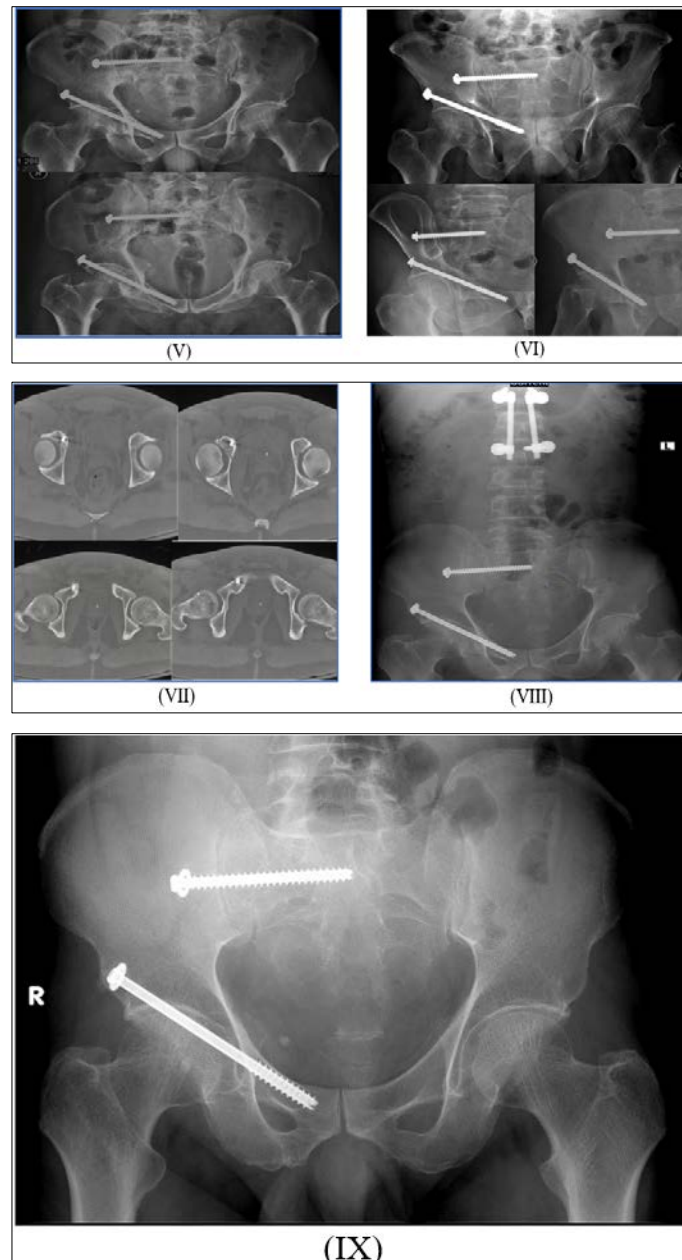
I: preoperative x ray. A anteroposterior view, B Inlet view, C outlet view. II: preoperative CT 3D reconstruction a AP projection, B inlet view, C outlet view, D right iliac view, E right obturator view. III: preoperative axial CT A showing iliosacral injury. B, C showing anterior column injury, D showing ischial ramus injury. IV: intraoperative fluoroscopic images A down the wing view showing fracture reduction by iliosacral compression, B final reduction and screw position on down the wing view to insure sacroiliac compression, B obturator Outlet view, D inlet view to insure position of anterior column screw. V: immediate post-operative X ray A Ap view, B inlet view. VI: immediate post-operative x ray A outlet view, B obturator oblique view, C iliac oblique view. VII: 1 postoperative axial ct showing fracture reduction and anterior column screw position. VIII: 3 month postoperative xray Ap view. XI: 6 month postoperative xray Ap view
